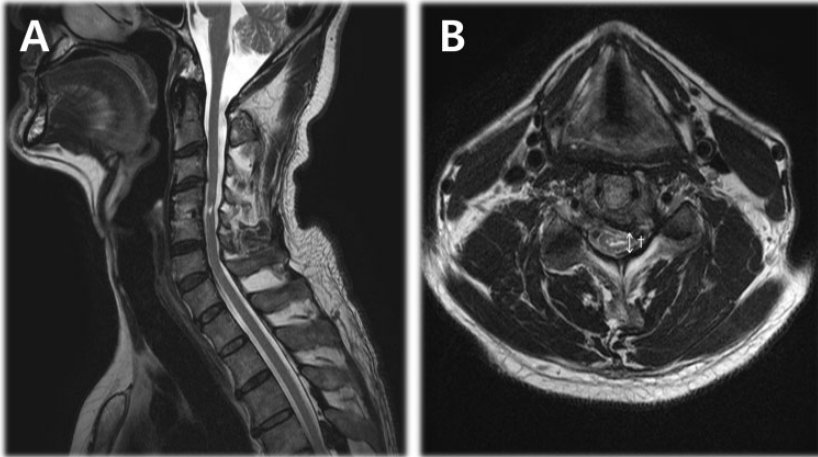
Sagittal (A) and axial (B) magnetic resonance images of a 59-year-old male patient (case 1) that presented with severe pain in both upper extremities secondary to a suspected spinal cord injury subsequent to a cervical interbody fusion surgery at C4–C5. He complained of sharp, tingling and scratching pain over 9 years and paroxysmal pain similar to an electric shock lasting approximately 5 min, more than 20 times a day. Myelomalacia was observed between the C4 and C5 levels. †The narrowest region of the anteroposterior diameter of the cervical canal was 6.95 mm at the C4/C5 level, which was anticipated to cause difficulty in inserting the lead.
